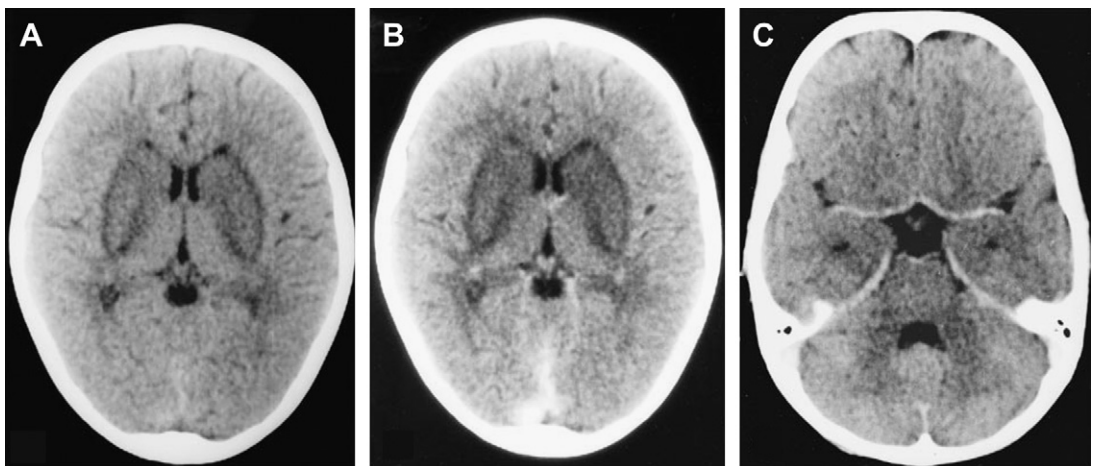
Rabies. (A–C) Noncontrast (A) and contrast-enhanced (B, C) CT scans show nonenhancing bilateral basal ganglia hypodensities. (From Awasthi M, Parmar H, Patankar T, et al. Imaging findings in rabies encephalitis. *AJNR Am J Neuroradiol* 2001;22:678; with permission.)
